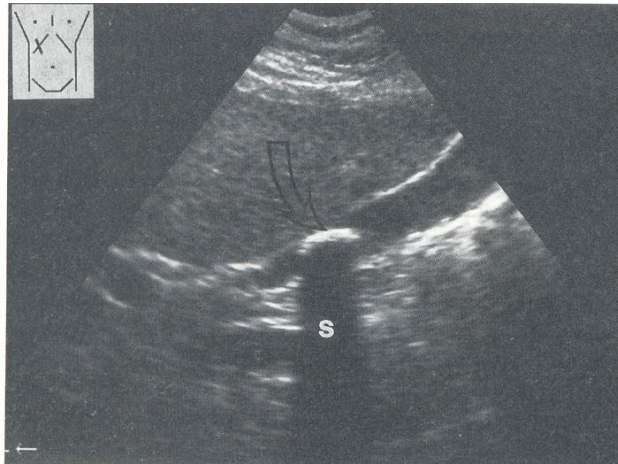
sonographic appearance of gallstone
